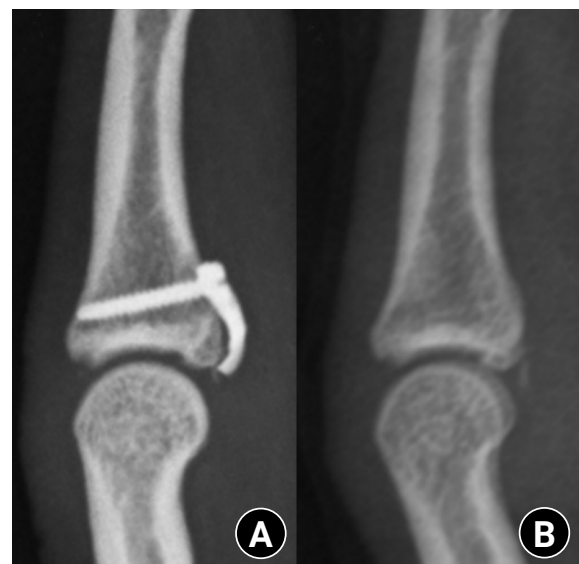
Radiographs during follow-up. (A) Bone union after treatment with the hook plate. (B) Appearance after implant removal.
